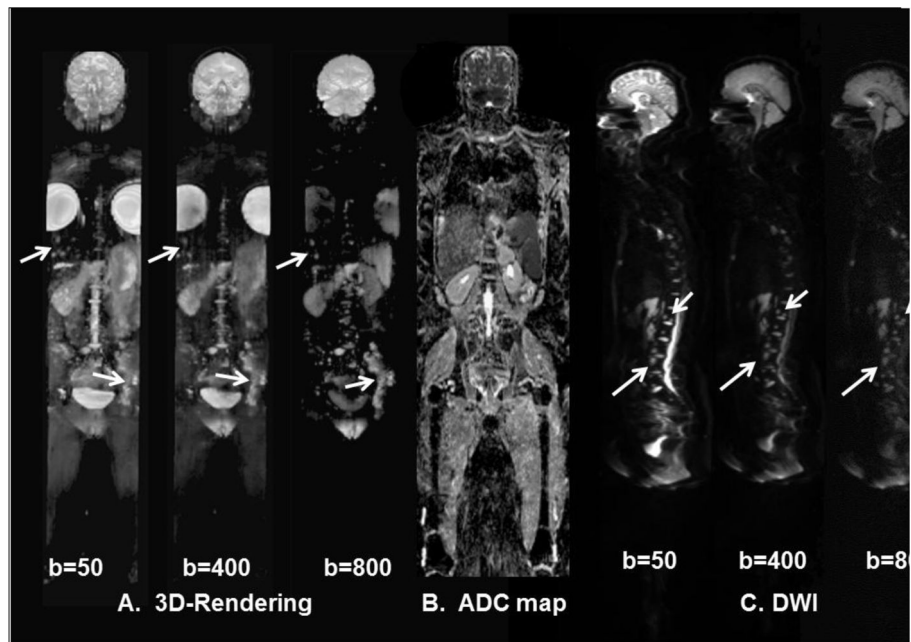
Demonstration of the of the WB-DWI in a 46-year-old- woman with metastatic breast cancer. A.) Three-dimensional visualization of metastatic lesions using different b values from the DWI. There are progressive changes in the DWI signal intensity within the metastatic sites (white arrows) of the left pelvis, thoracic and lumbar spine, and liver. B.) A coronal ADC map through the midsection of the patient. C.) Different b-values from WB-DWI sagittal images of the spine showing multiple metastatic regions.
